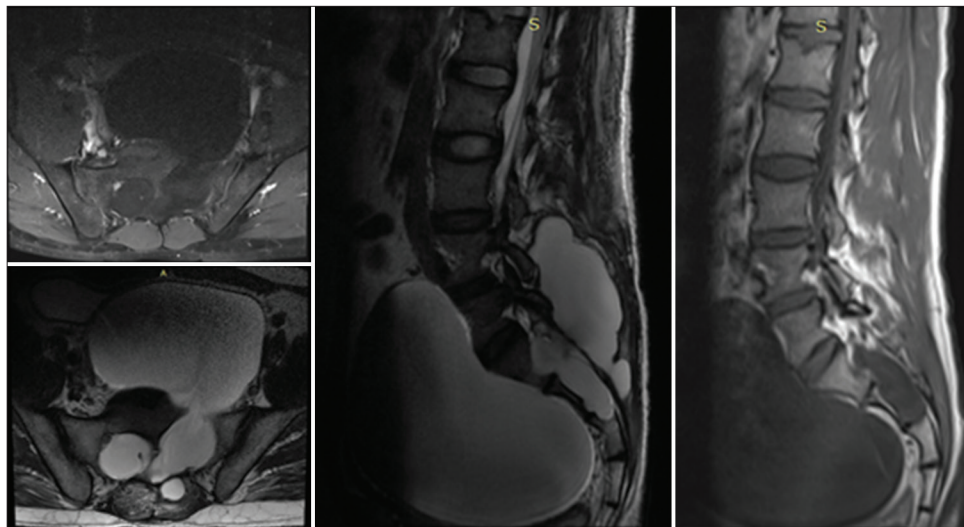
Axial and sagittal magnetic resonance imaging scan of Lumbo-Sacral (LS) spine 6 months after index surgery. T1-hypointense and T2-hyperintense lesion is seen reappearing in the pelvic cavity. Posteriorly, the collection of cerebrospinal fluid can be noted at the level of surgery/laminectomy.
